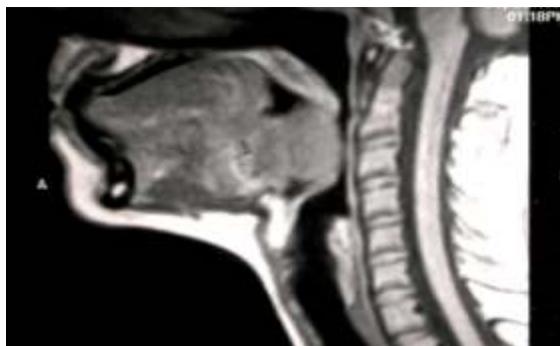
MRI of Head & Neck region-Sagittal cut showing tumour in midline tongue base
